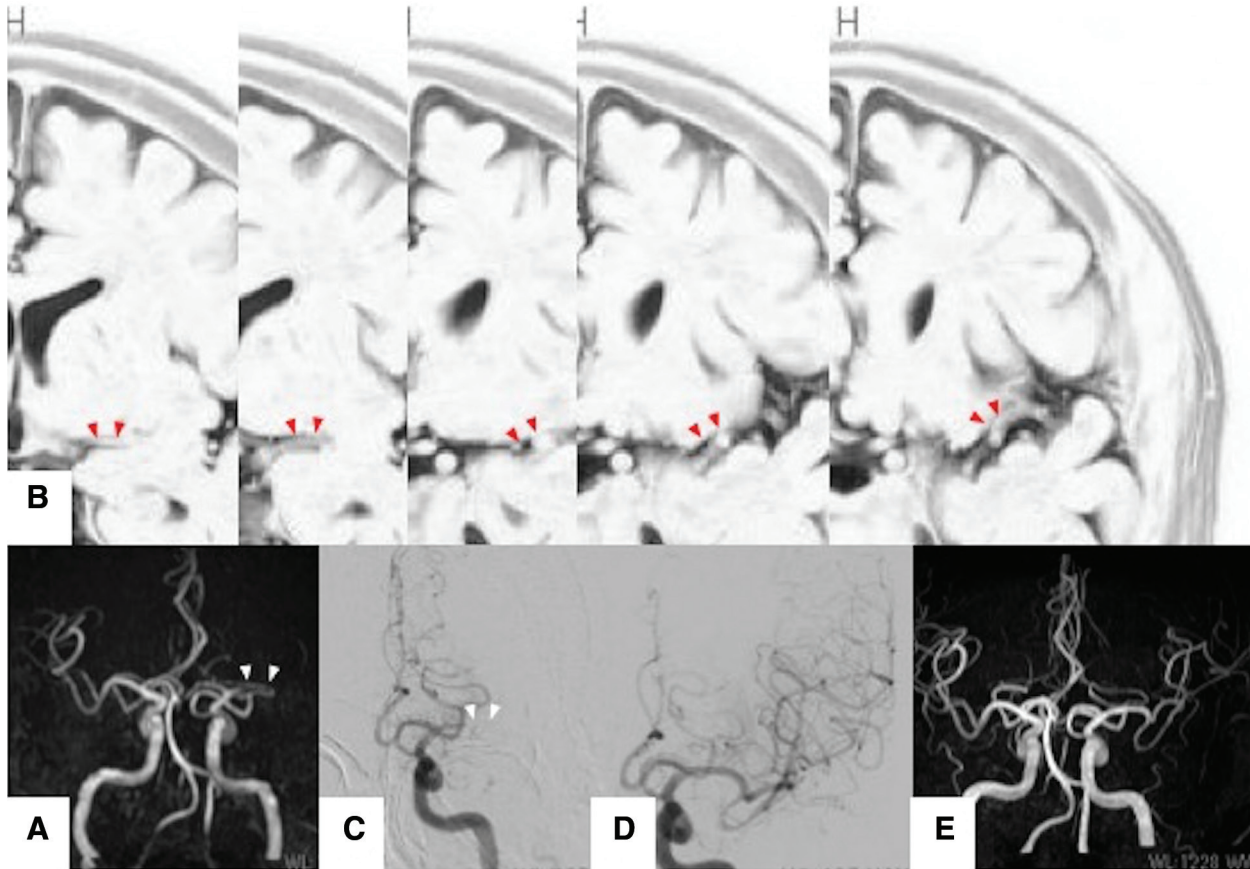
A 54-year-old man with consciousness disturbance, left conjugate deviation, and right hemiparesis. (A) MRA on arrival shows right M1 occlusion. (B) MAS-MRI shows part of M1, although it was difficult to visualize in full because part of M1 contacted the brain. (C)
